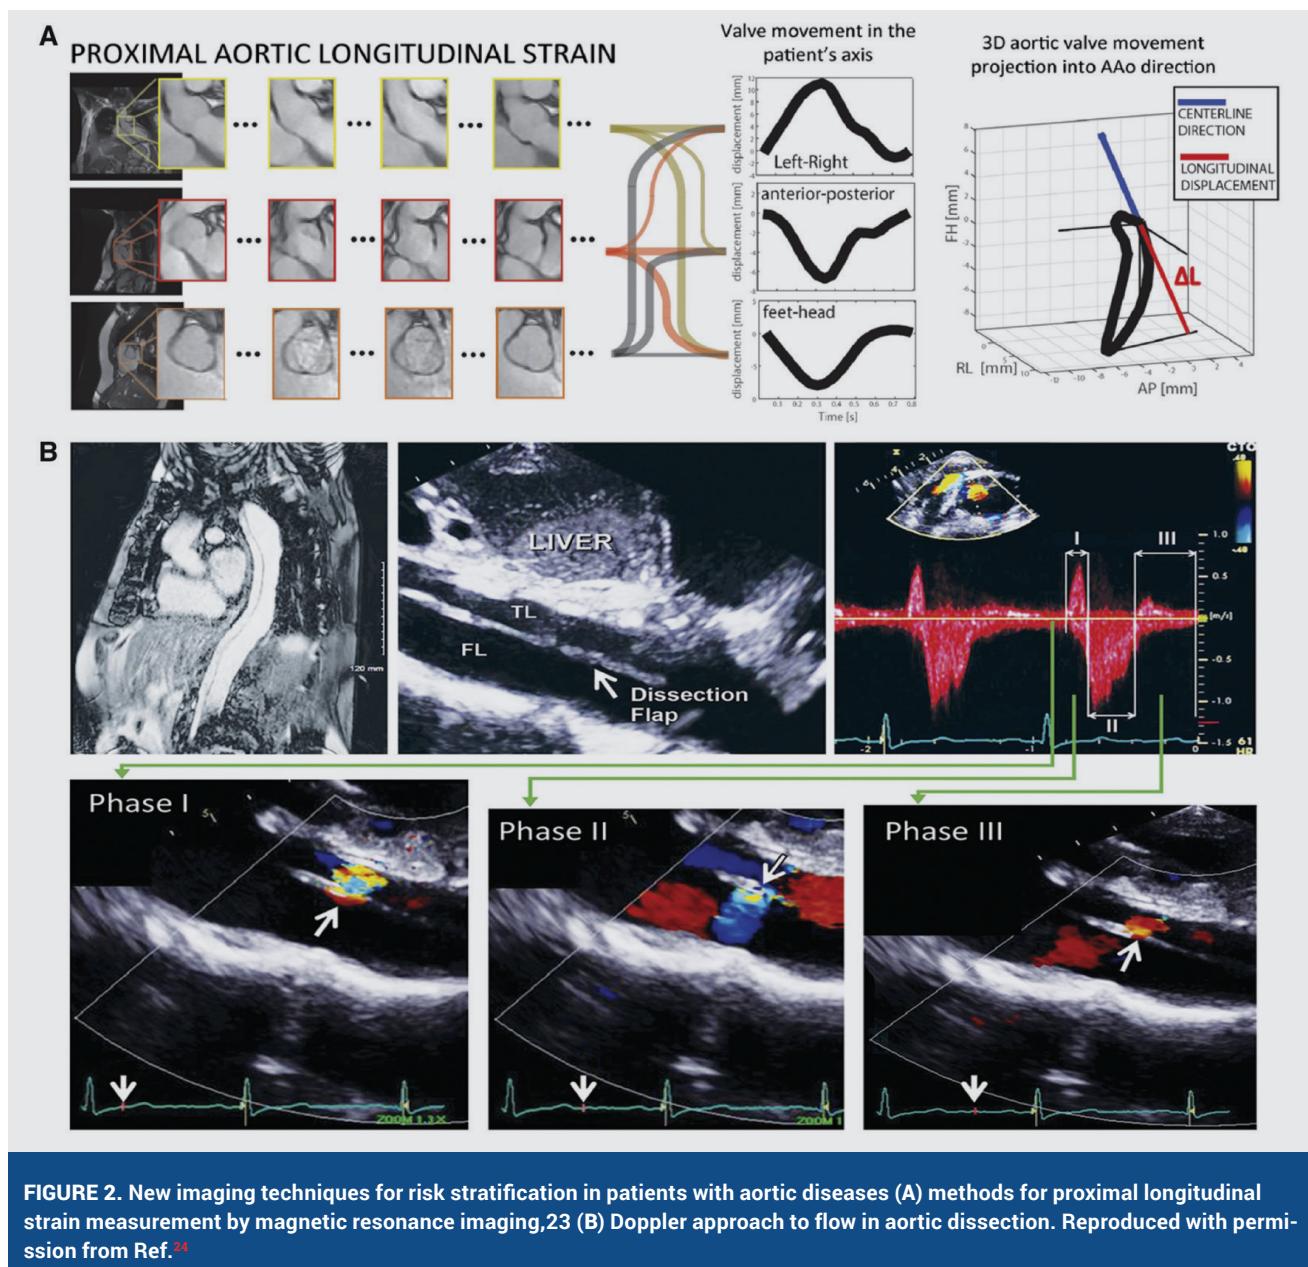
New imaging techniques for risk stratification in patients with aortic diseases (A) methods for proximal longitudinal strain measurement by magnetic resonance imaging,²³ (B) Doppler approach to flow in aortic dissection. Reproduced with permission from Ref.²⁴
